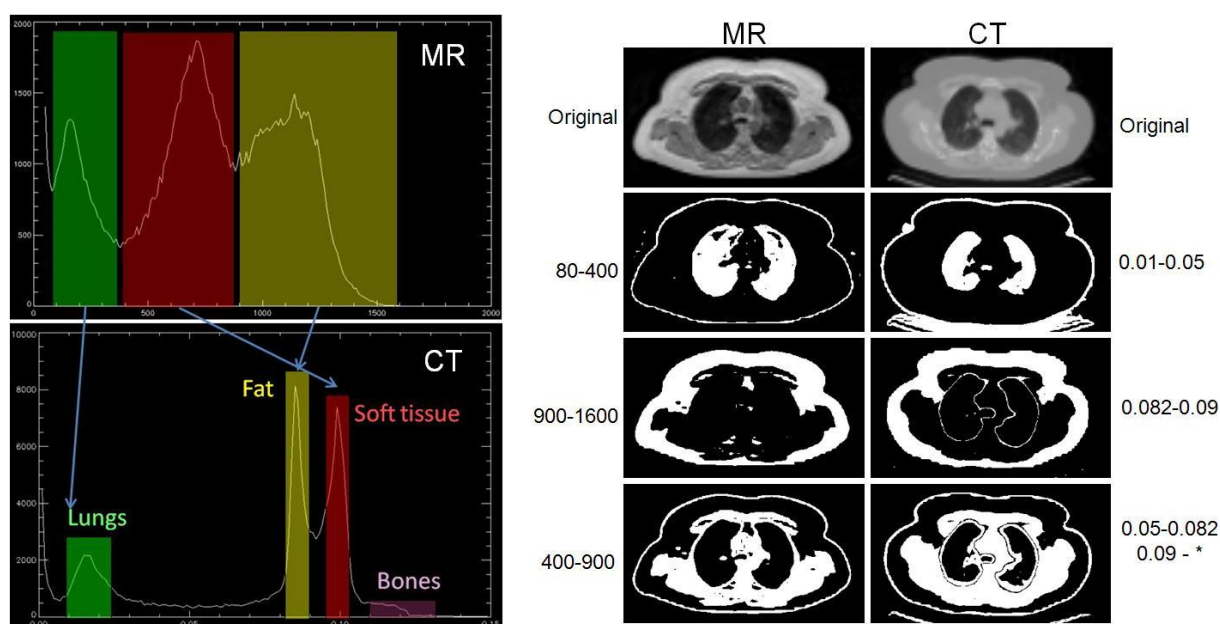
On the left, best case histogram acquired using the proton-weighted sequence. Here, four peaks can be easily separated, corresponding to each of the main four peaks observed in the CT histogram. On the right, intensity-based separation shown on the image space. A reasonable agreement between both segmentations can be observed despite an incorrect spatial registration. From top to bottom: original image, lung, fat, and soft tissue compartments.
